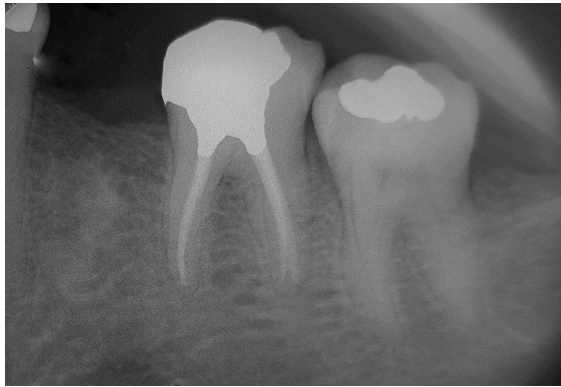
Periapical radiographs of tooth #19; A) Diagnostic periapical radiograph; B) Periapical radiograph shows an endodontic file in the third distal canal; C) Master-cone-confirmation periapical radiograph; D) Final radiograph; 5 canals were obturated
